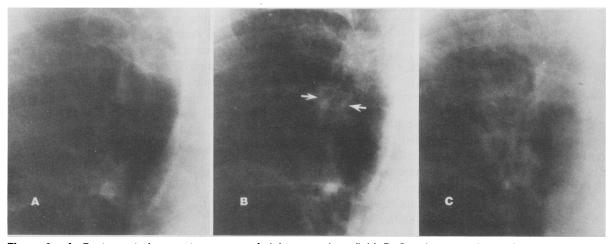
A, Posteroanterior roentgenogram of right upper lung field. B, Growing mass (arrows) 16 months later, not reported. C, A year later, the mass is larger. Squamous cell carcinoma was found on needle aspiration of the lung.
